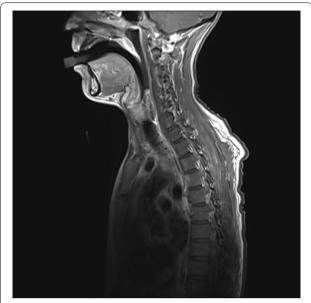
Magnetic resonance imaging demonstrating the gag in the nasopharynx and laryngopharynx
